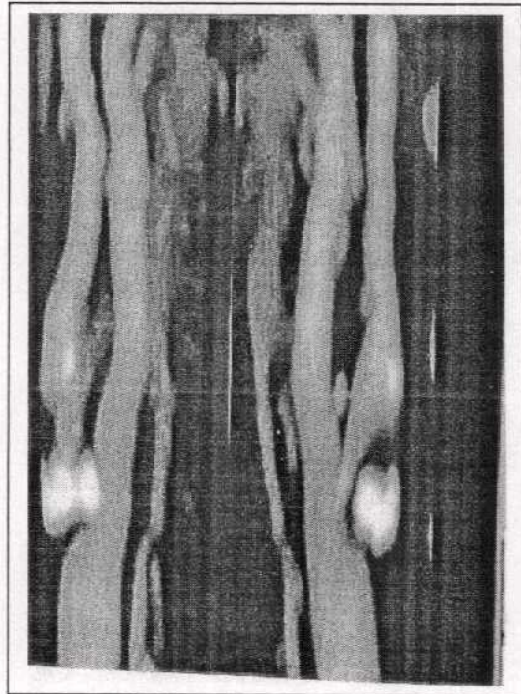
Spiral CT Angiography shows plaque at origin internal carotid artery (*Quoted from Suttonl., 2002*).
